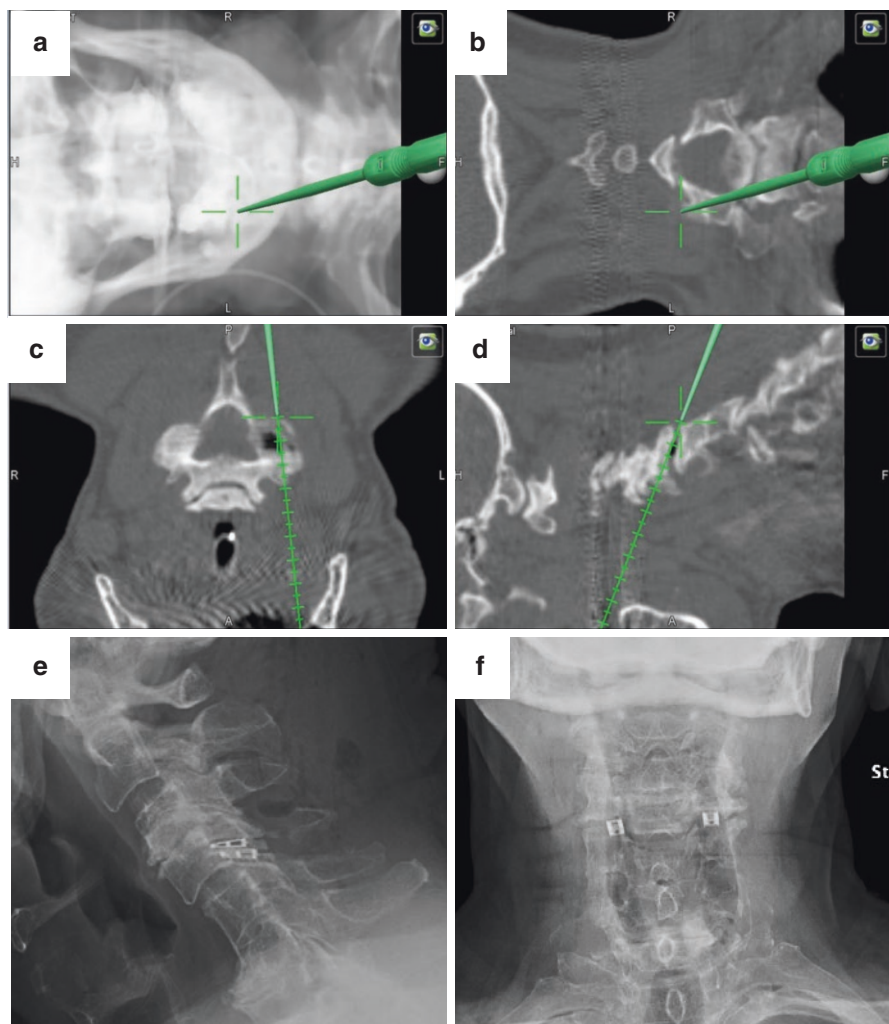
(a–d) Intraoperative 3D navigation pictures showing the trajectory and position of the interfacet cage. Postoperative (e) lateral and (f) anteroposterior radiographs after bilateral interfacet joint cage implantation
